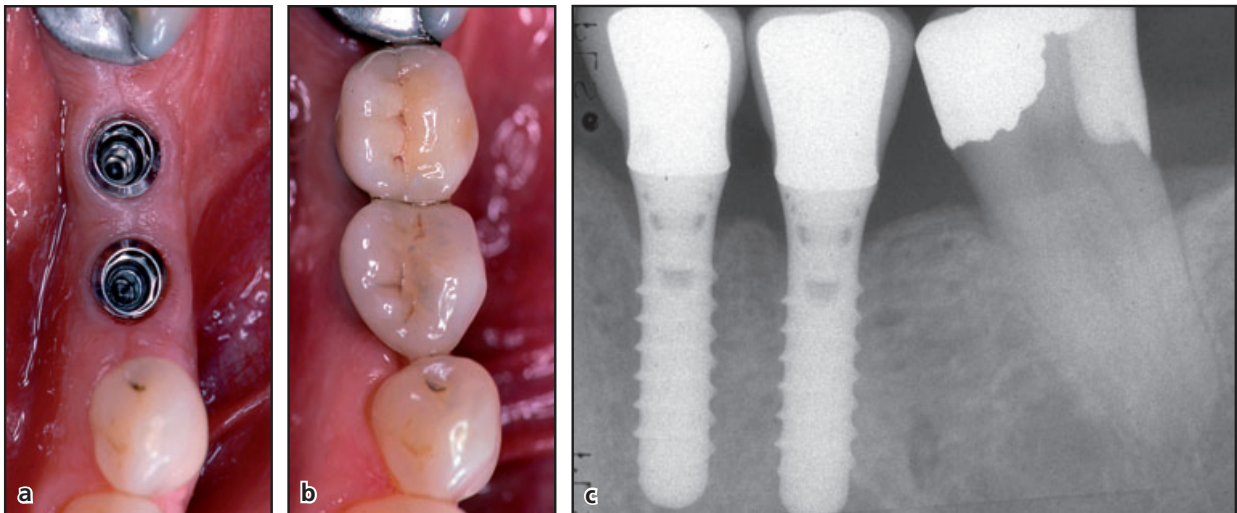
Increasing subjective chewing comfort by closing a mandibular gap. (a) Installation of two standard (4.1 mm diameter) Straumann® implants (10 mm), 5 mm distal to the distal aspect of tooth 34 and 12 mm distal to tooth 37. Total extension of the gap: 18 mm. (b) Reconstruction of the implants in premolar units to fit the size of the gap. (c) Radiographic documentation, 6 years after loading. The filling on tooth 37 was satisfactory and did not need replacement.
